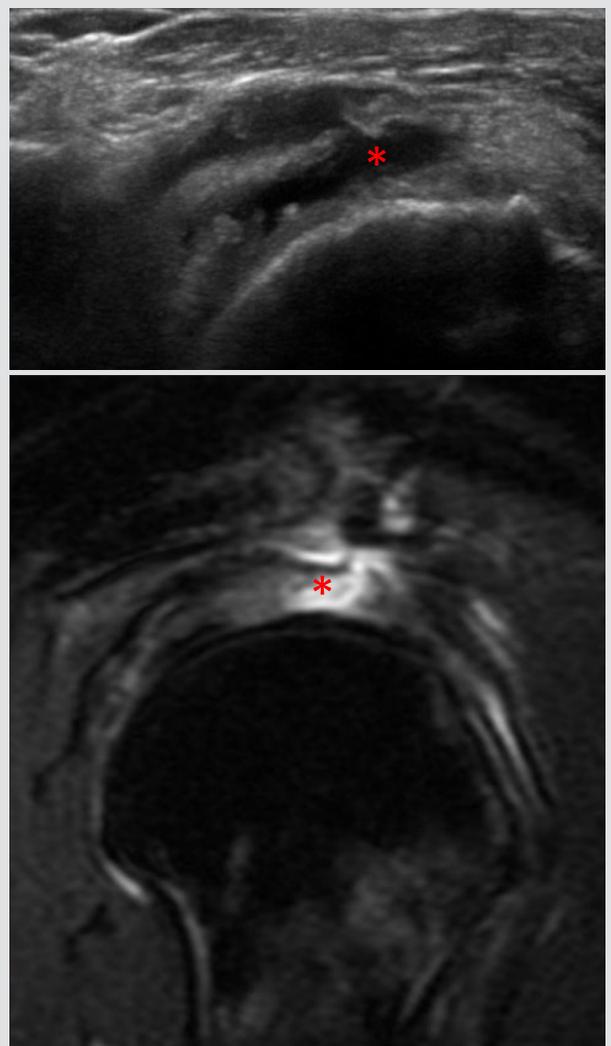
Full thickness supraspinatus tear (*) on ultrasound (top image) in short axis and in sagittal plane on shoulder MR.
